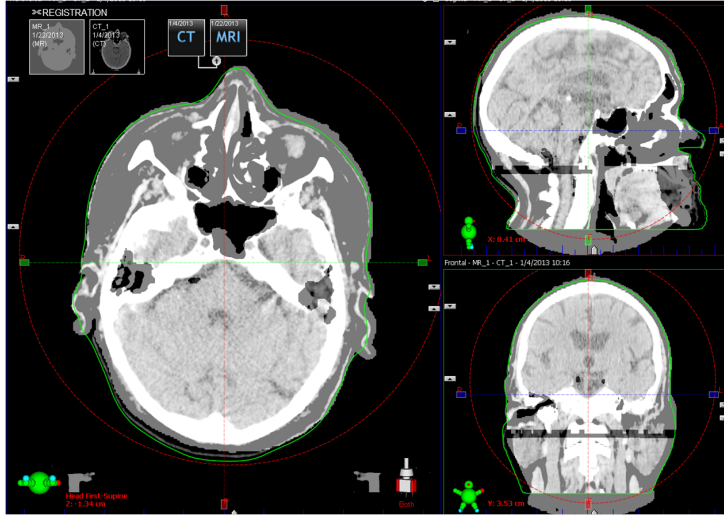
Manual rigid registration of CT and sCT scan.
